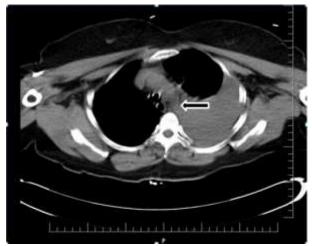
Icy glass appearance in left perihilar zone on contrasted thorax CT
